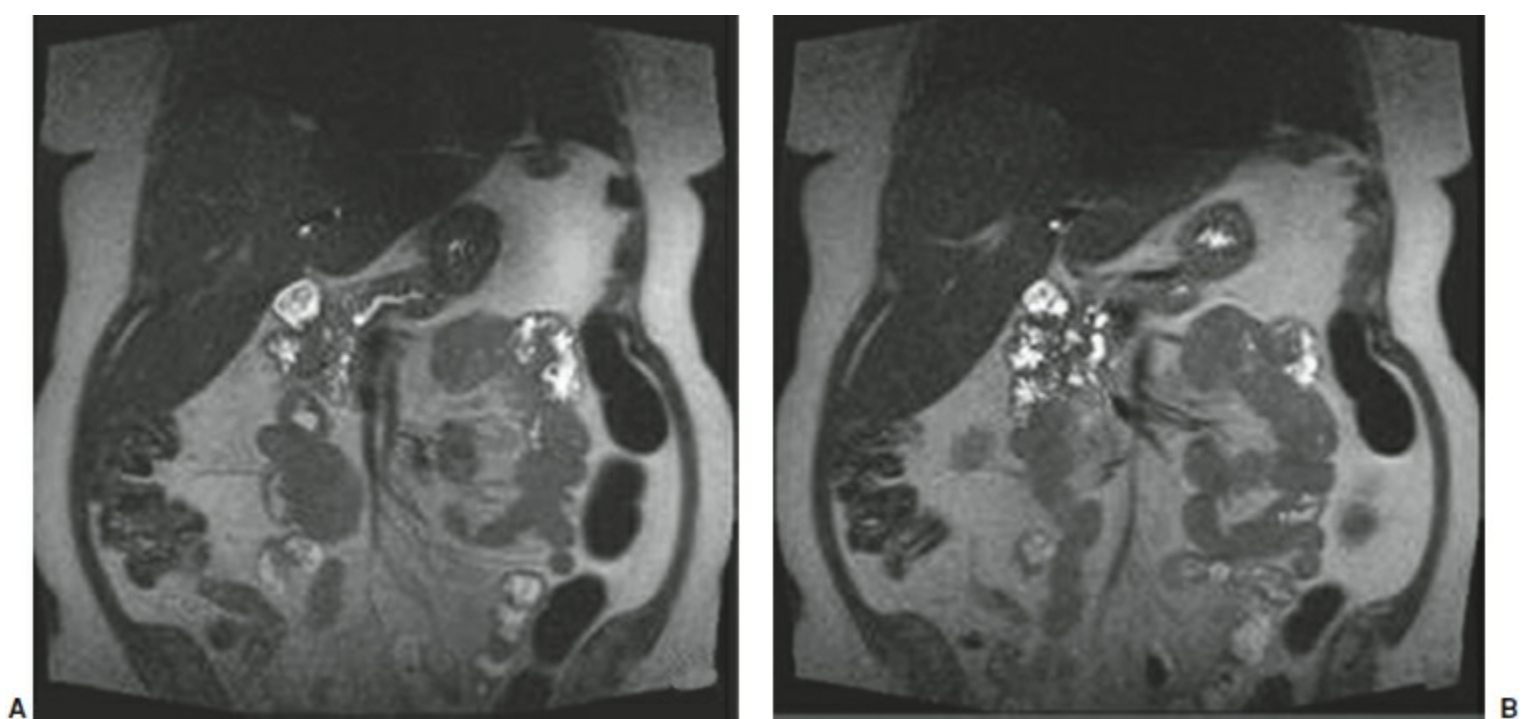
T2-weighted magnetic resonance imaging with secretin stimulation demonstrate a pathologically dilated pancreatic duct in the body of the pancreas (A), and cystic changes and dilated ducts in a fibrotic and inflammatory head of the pancreas (B).
